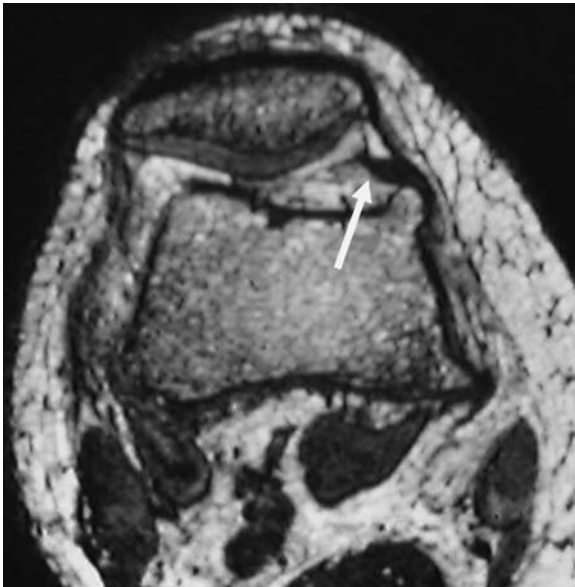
Medial patellar plica. Axial MRI showing low signal mass in the medial synovial recess. In this case there is an associated bony spur seen at the site of impingement
